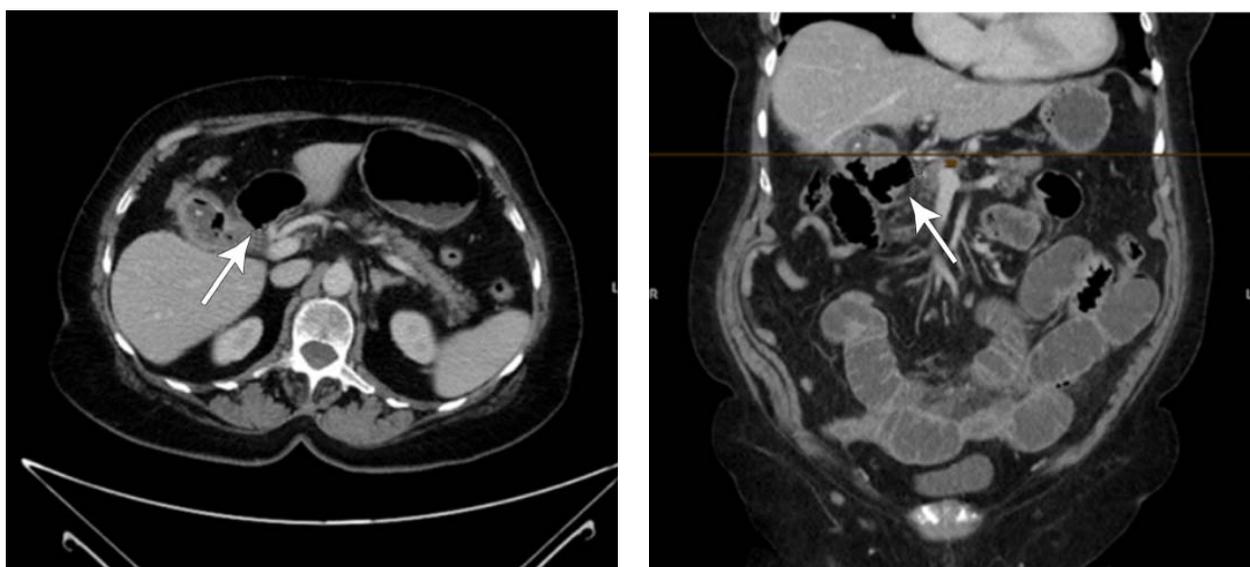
Abdominal CT findings cholecystoduodenal fistula (cystoduodenal fistula and aerobilia are indicated by arrows)
